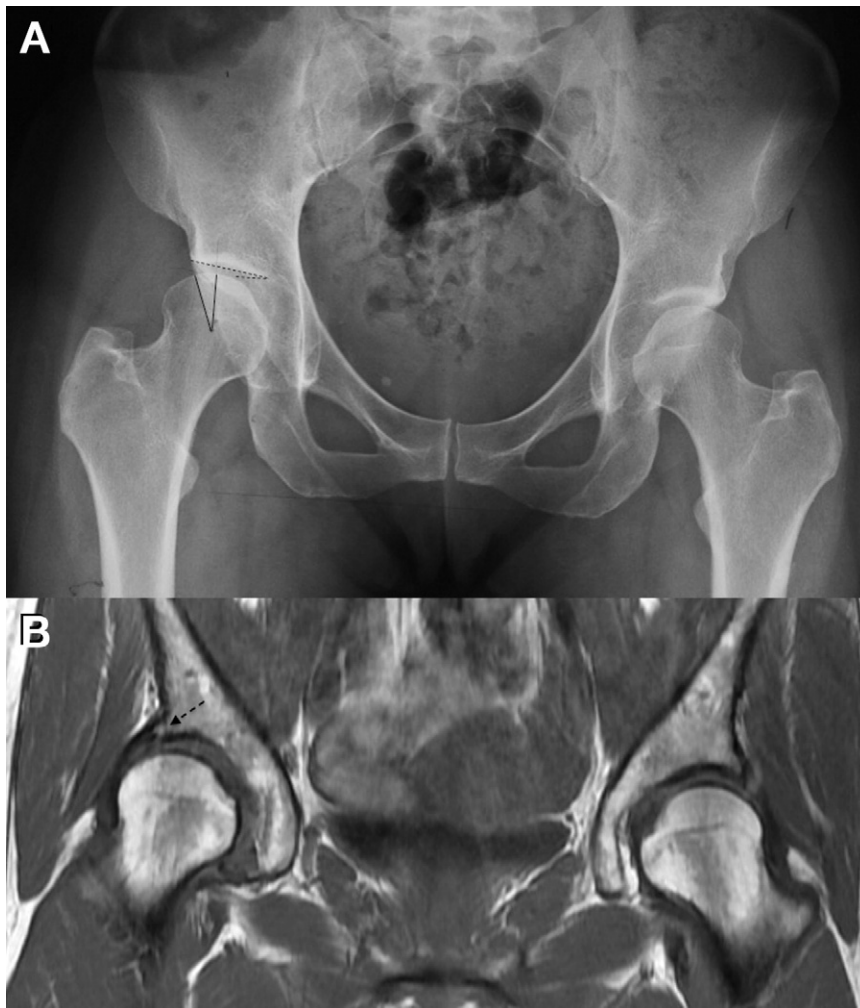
(A) Preoperative radiograph of patient with right hip pain shows normal joint space, mildly increased anteversion, and mild anterolateral dysplasia with a CEA of 22° (solid lines), a sourcil angle of 11° (dashed lines), and less than 75% head coverage. (B) Magnetic resonance imaging emphasizes the radiographic findings and shows significant anterolateral labral tear (arrow) and a sublabral cyst.
